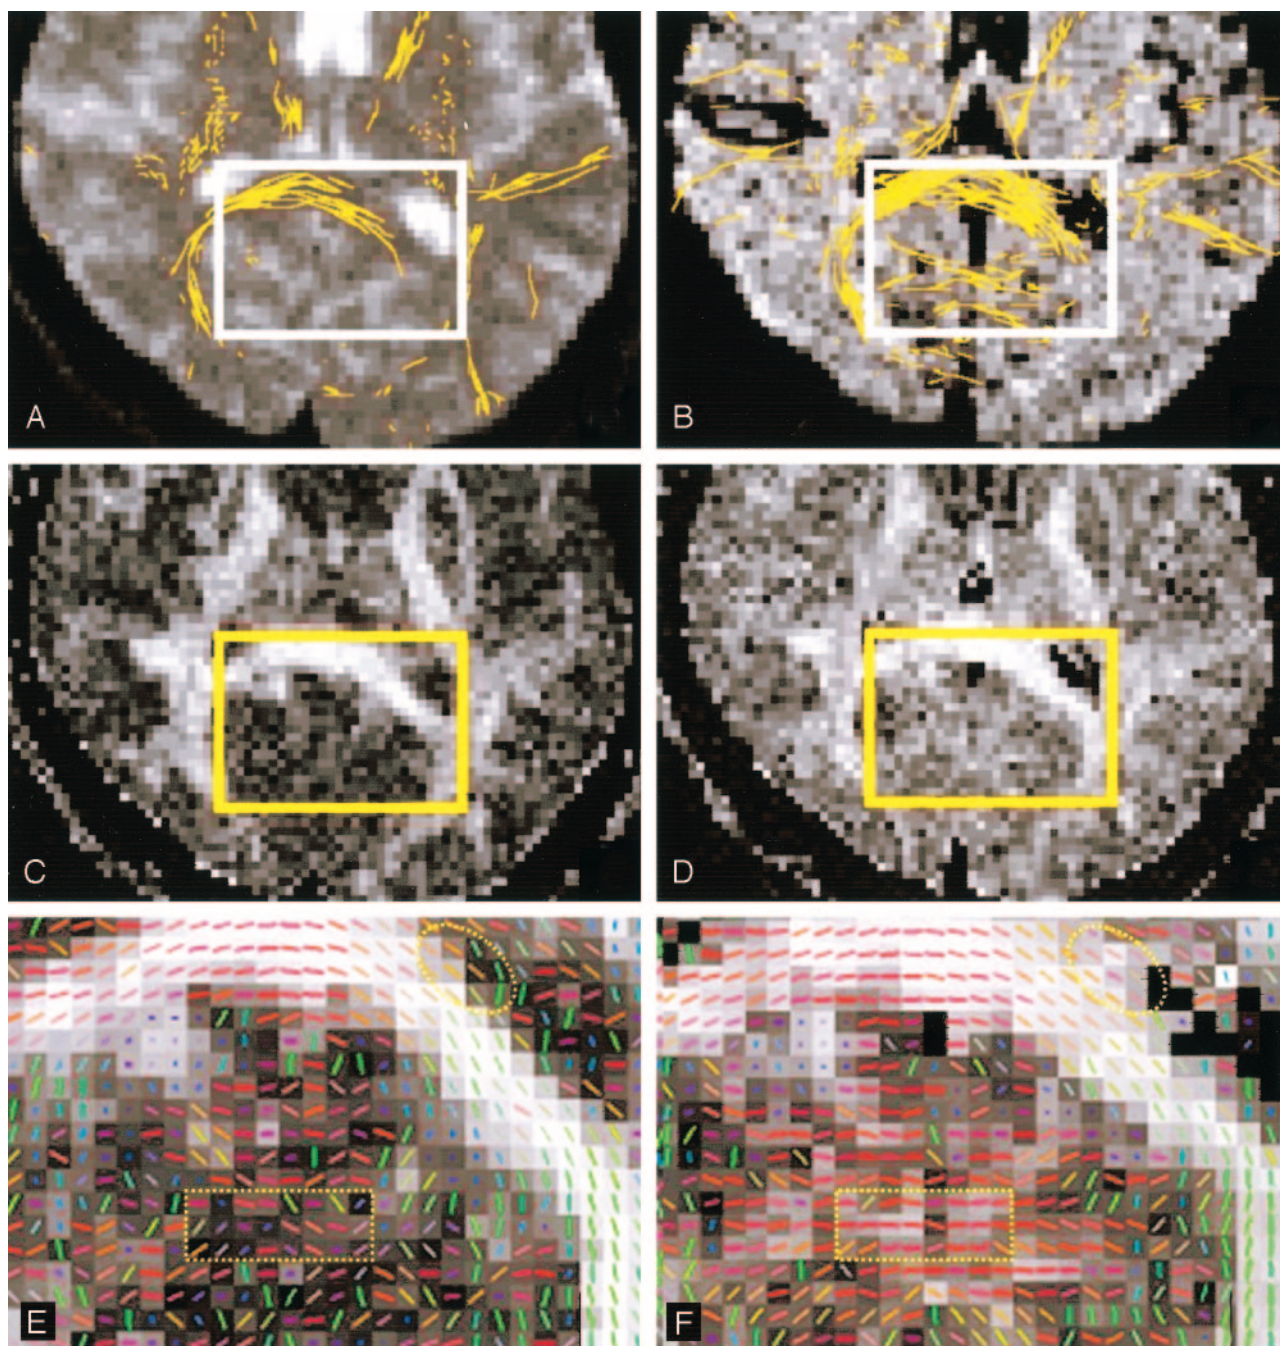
Posterior aspects of the same image section as in Figure 2 show white matter tracts superimposed on the images in A–F magnified from the rectangular region-of-interest (solid rectangles). Although the FLAIR DTI tractogram shows more tracts in the splenium of the corpus callosum (B and dashed oval in F, with more consistent fiber directions) than the conventional DTI tractogram (A and dashed oval in E, with less consistent fiber direction near the lateral ventricle), false tracts are found in the occipital lobes (B).
